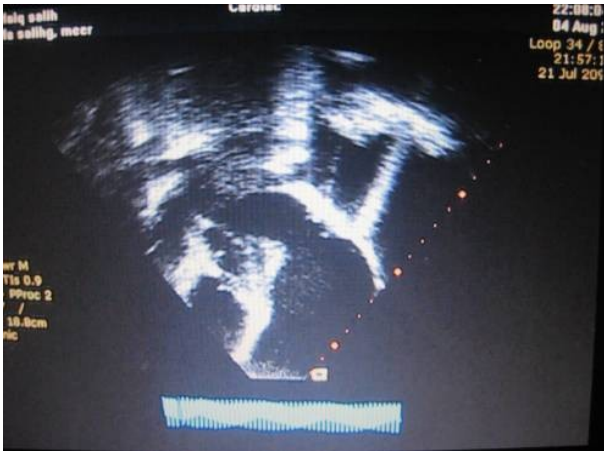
Transthoracic echocardiography, showing large cavity next to the Left Ventricle in four chamber view.
